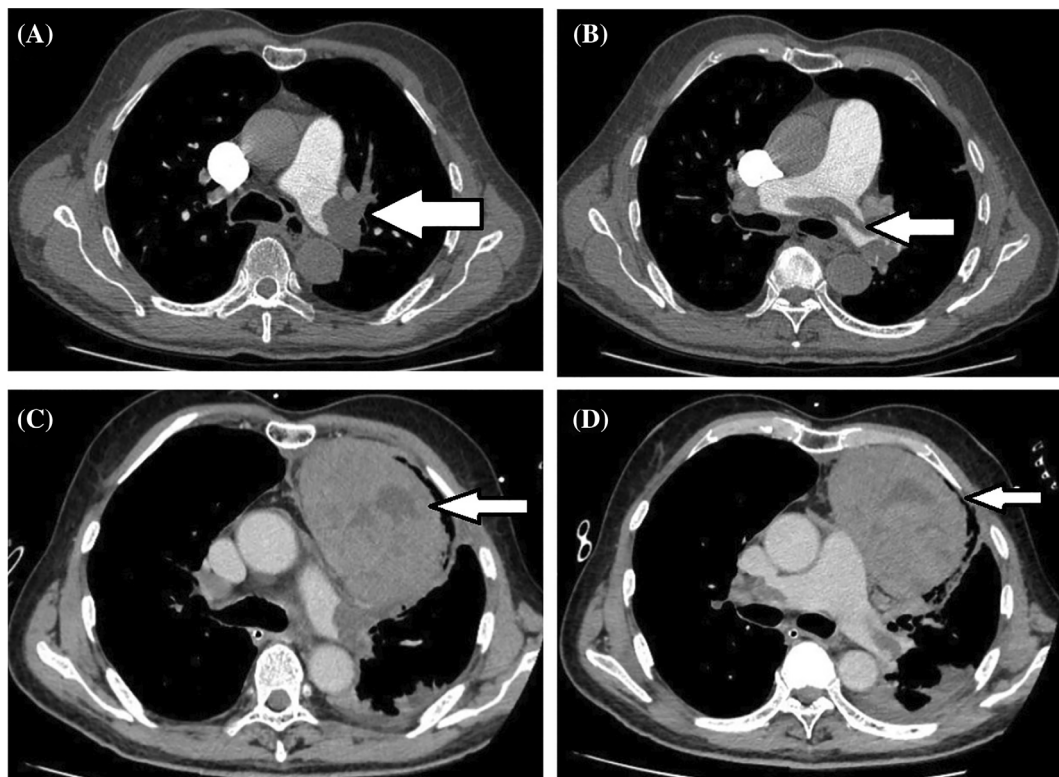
(A, B) CT Pulmonary Angiogram showing a saddle embolus extending into the left main pulmonary artery; (C, D) CT angiogram post-thrombolysis showing encapsulated anterior mediastinal hematoma compressing the mediastinal structures.
